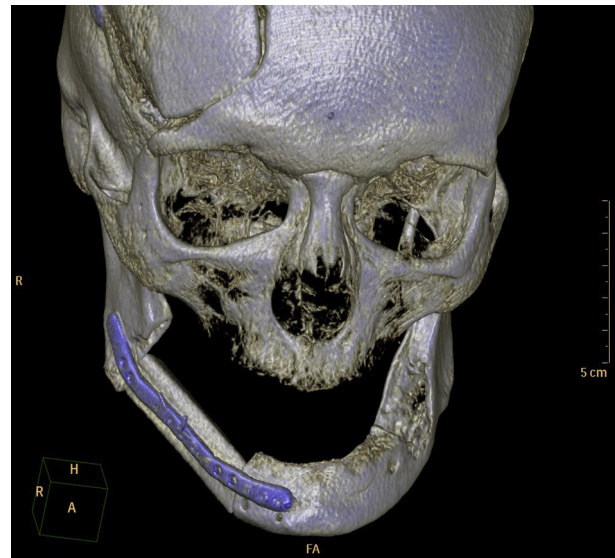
Postoperative evaluation with computed tomography scan in patient 5 (same patient shown in Figs 1-4). Good alignment and stable contact between bone segments were reached. A, anterior; FA, foot anterior; H, head; R, right.
